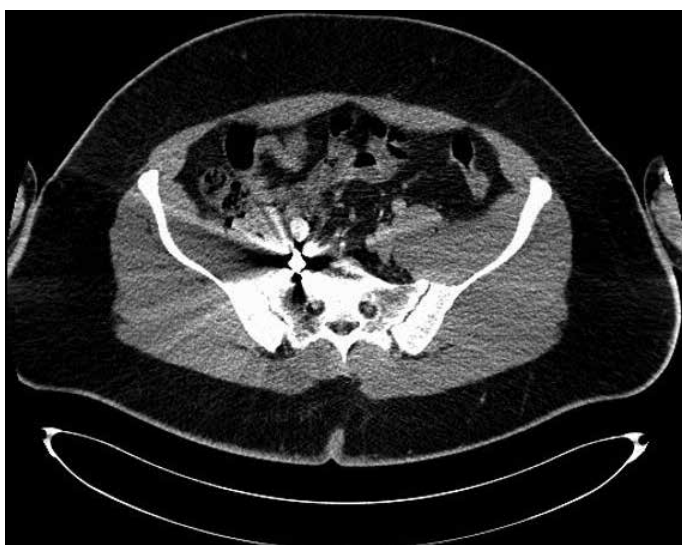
Computed tomography of the final localization of the bullet after 1 year
